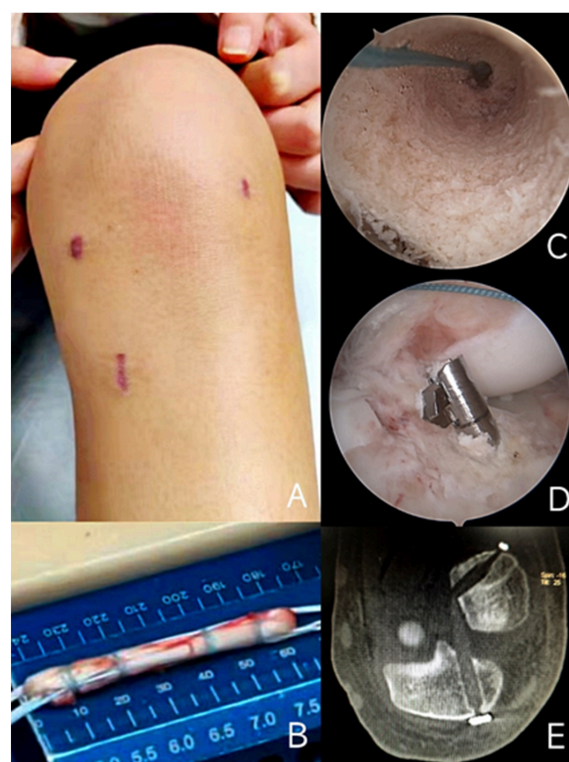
Surgical technique. (A) The anteromedial and anterolateral portal and tibial incision. (B) Four strand tendon graft by using single semitendinosus muscle tendon. (C) The internal view of femoral bone socket. (D) The construction of tibial bone socket with flipcutter. (E) A postoperative CT show Bone tunnel and suspension device by using all-inside technique.
